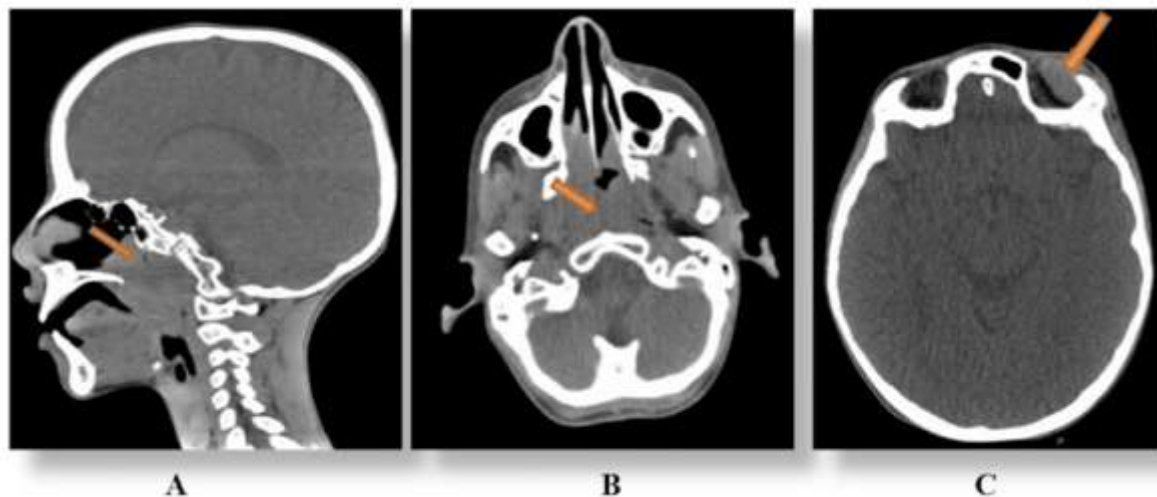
CT scan of the brain in sagittal view (A) and axial views (B) and (C).
